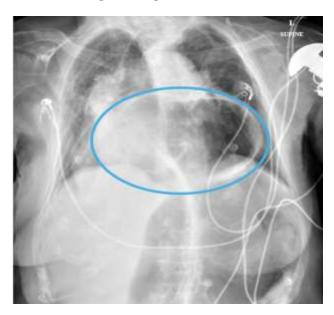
Chest radiography showing herniation of the apex of the sigmoid volvulus into the thoracic cavity (blue circle).
